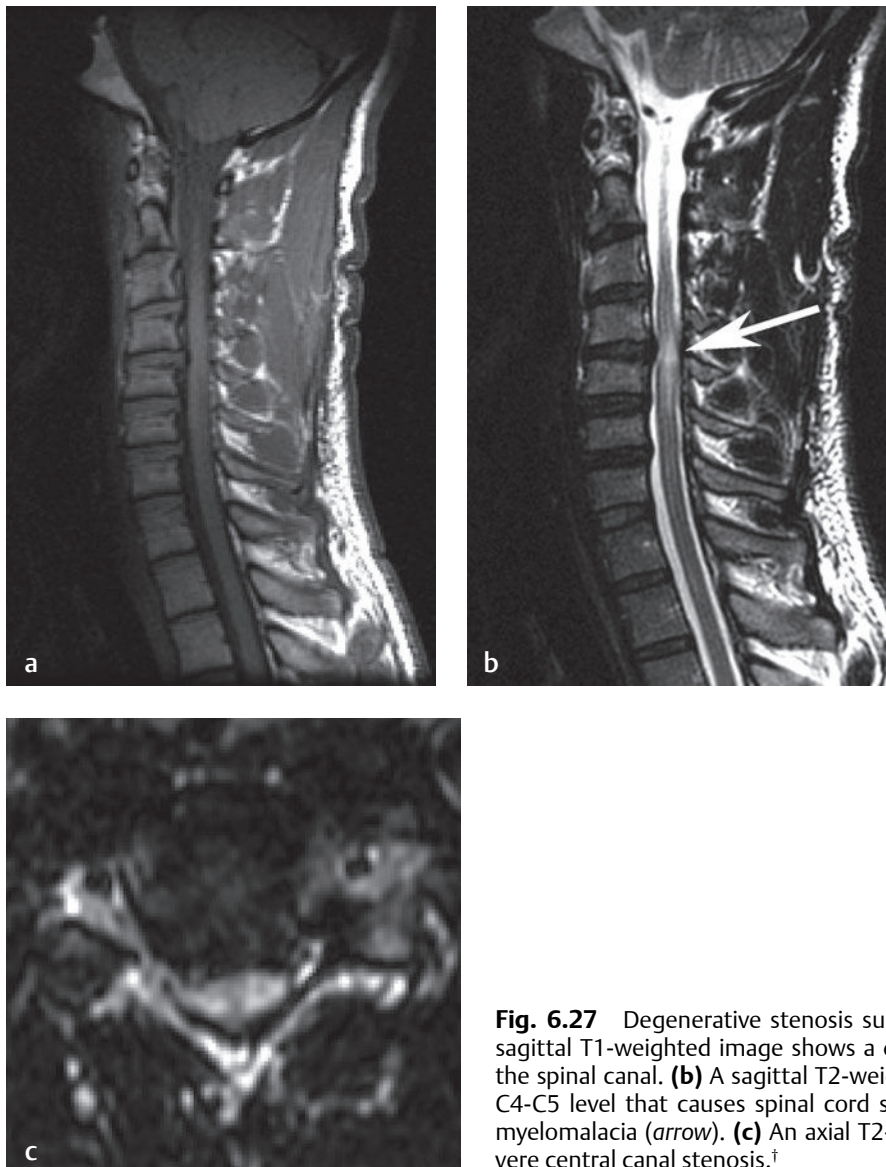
Degenerative stenosis superimposed upon congenital stenosis. (a) A sagittal T1-weighted image shows a developmentally shortened AP dimension of the spinal canal. (b) A sagittal T2-weighted image shows a small disc bulge at the C4-C5 level that causes spinal cord signal abnormality, representing spondylotic myelomalacia (arrow). (c) An axial T2-weighted image shows the moderate to severe central canal stenosis.[†]
